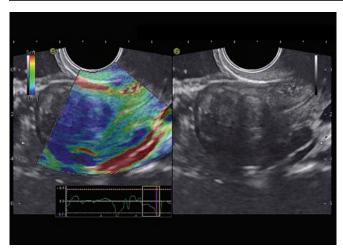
Transvaginal ultrasonographic B-mode and elastographic images in a woman with fibroids and adenomyosis. The fibroid is easily defined as a round-shaped blue area in elastography mode. The adenomyotic area is exhibited as softer area (red and yellow) in the adjacent right side of the fibroid
